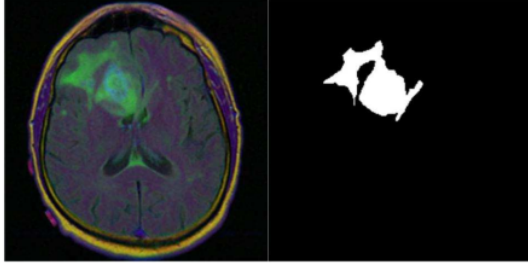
An example image of a brain MRI FLAIR scan (left) with its associated mask marking the area of the glioma (right).
